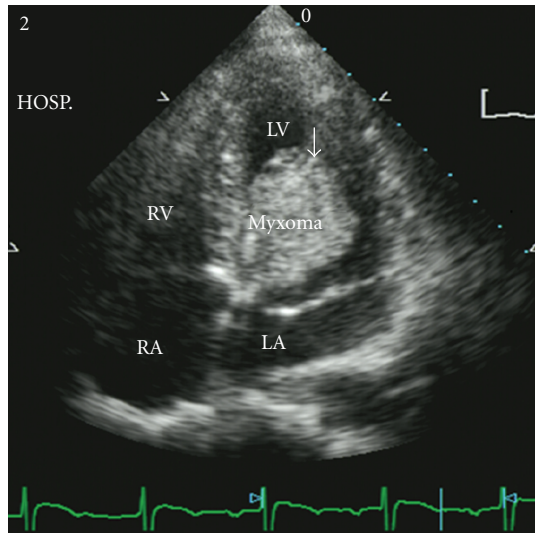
Transthoracic echocardiogram from apical 4-chamber view showed one myxoma (arrow) in the left ventricle with diameter 3×4 cm and stalk on middle interventricular septum.
